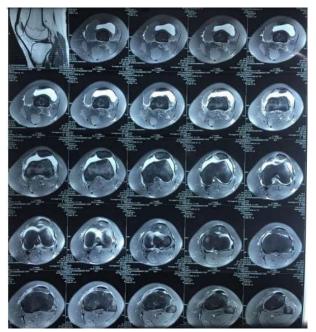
MRI left knee (axial T2 FS): hyperintensities involving lateral condyle of femur, mild joint effusion and lateral patellar subluxation with partial tear of medial retinaculum.
